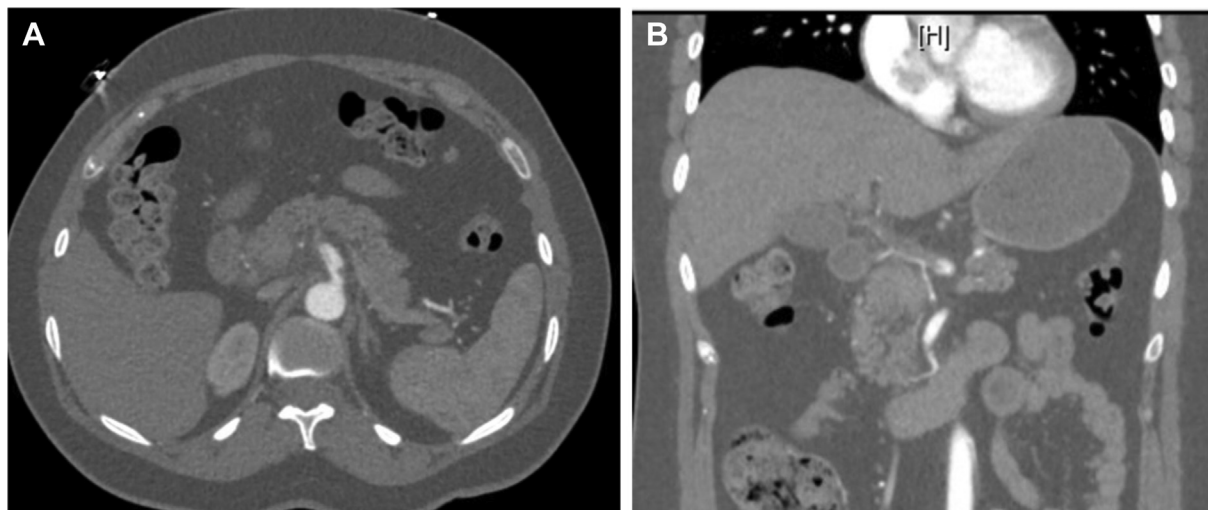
Preoperative axial (A) and coronal (B) computed tomography angiography (CTA) showing distal celiac artery dissection with extension to the common and proper hepatic arteries. This resulted in limitation of flow and reconstitution of the left and right hepatic arteries from the pancreaticoduodenal arcade.
